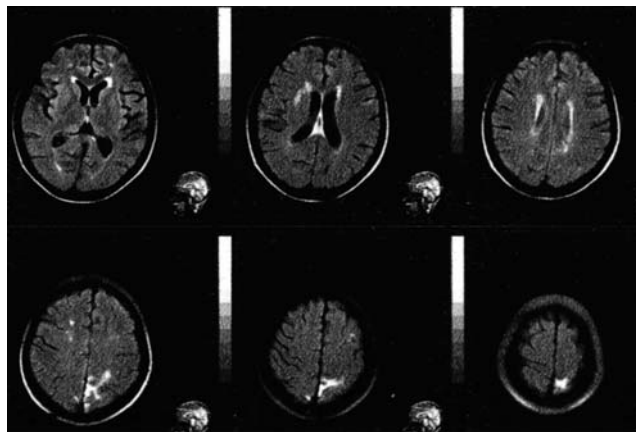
Magnetic resonance imaging of the brain (August 25, 1997, T₂-weighted imaging) showing multiple high-intensity lesions in the cortex or subcortical white matter of the left occipital and parietal lobes, the white matter of both frontal lobes, and the deep white matter around the right ventricle
